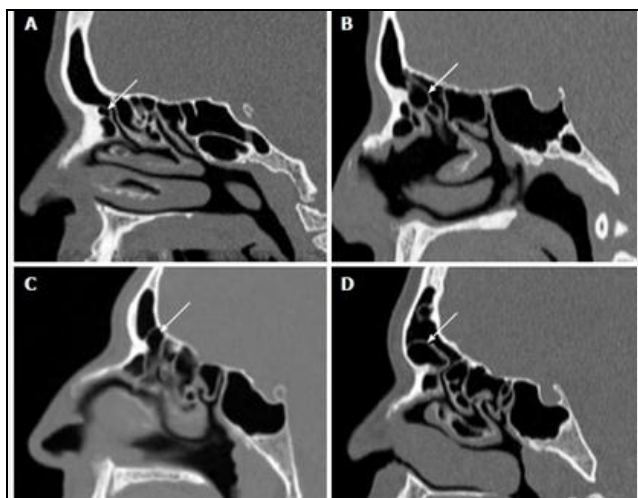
Sagittal Plane of CT Shows Types of Frontal Air Cells: Arrow Shows. A-Type1; B-Type 2; C-Type 3 and D-Type 4 (Kuhn Cells)
